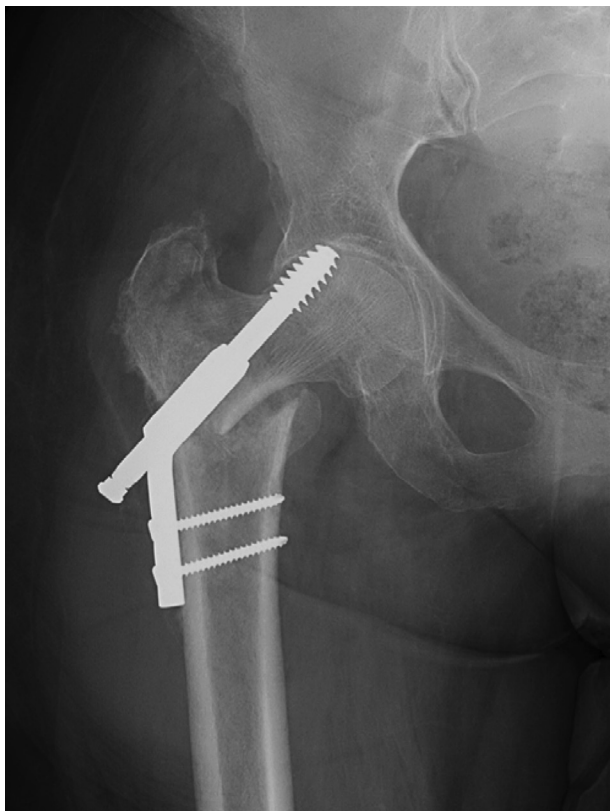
X-ray showing fracture collapse and cut-out in 2-hole DHS system (from author's personal archive)
